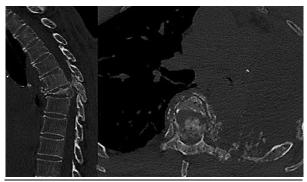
Preoperative computed tomography (CT) scan in sagittal view (on the left) showing kyphotic fracture of T6 and mainly 17. The axial view (on the right) shows extensive low-attenuation gelatinous masses involving the left pleura, lung, and adjacent vertebral body.
